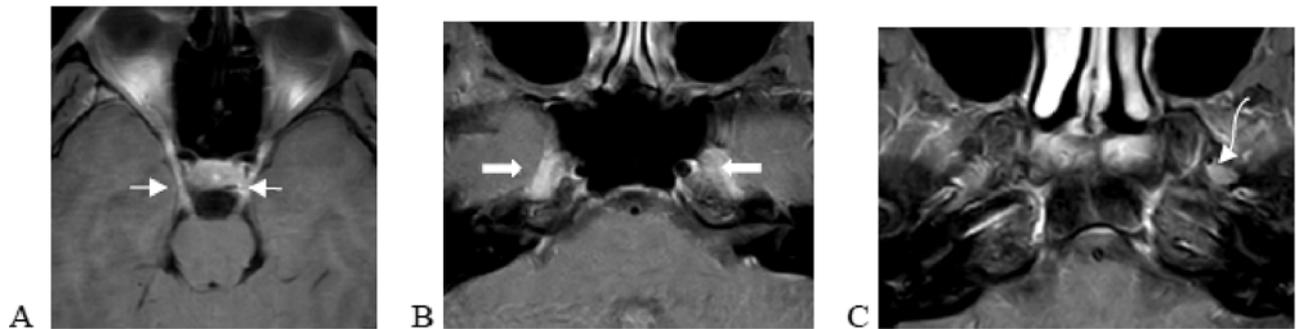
Case 2: lymphoma with CN involvement: A 43-year-old HIV-positive female patient presented with 2 weeks of progressive headache with bilateral CN III and CN V palsy. MRI of the brain axial post gadolinium T1WI demonstrated abnormal enhancement and smooth thickening of bilateral CN III (A, white arrows), thick enhancement of bilateral Meckel caves (B, white thick arrows) and asymmetrical prominent enhancement in left foramen ovale (C, white curve arrow).
